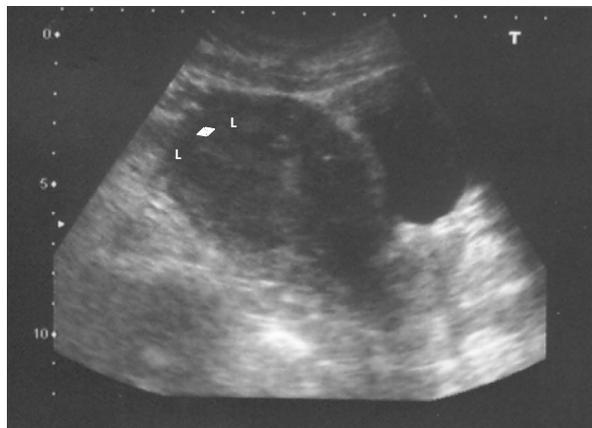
Ultrasound picture showing leiomyomas (L), one in the anterior wall and the other in posterior wall near to the fundus; endometrial thickness (\leftrightarrow) of 10 mm
